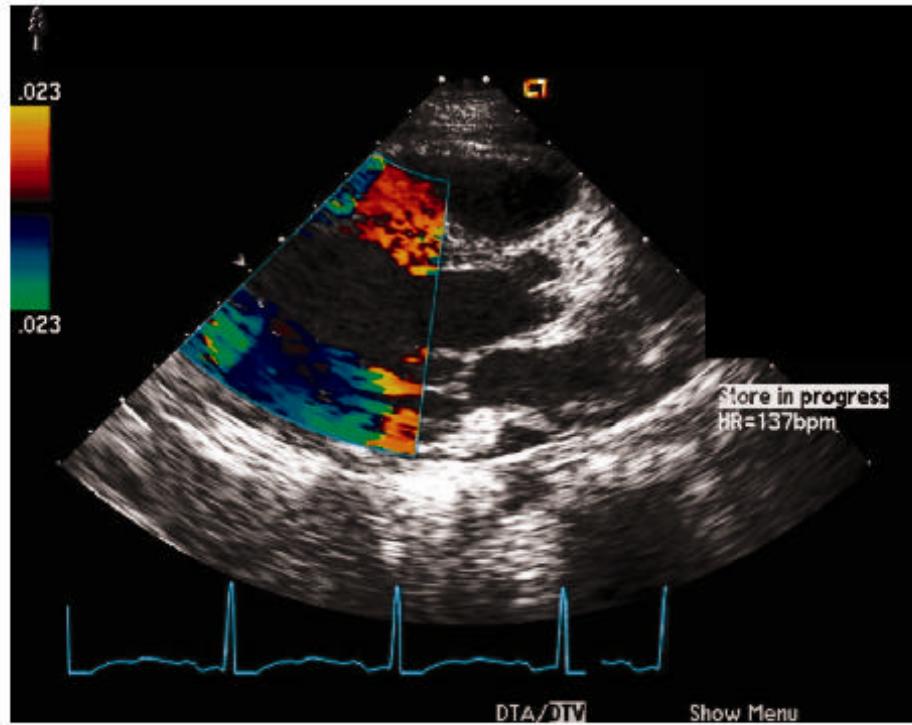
Color Doppler tissue imaging of radial motion of the septal and posterior left ventricular walls from a parasternal long-axis window in a child with normal intracardiac anatomy. As can be seen by the color Nyquist scale, mean myocardial velocities are very low-velocity (Nyquist limit 2.3 cm/s), in contrast to blood flow velocities within the heart (where the color Doppler Nyquist is ideally 80-100 cm/s).
